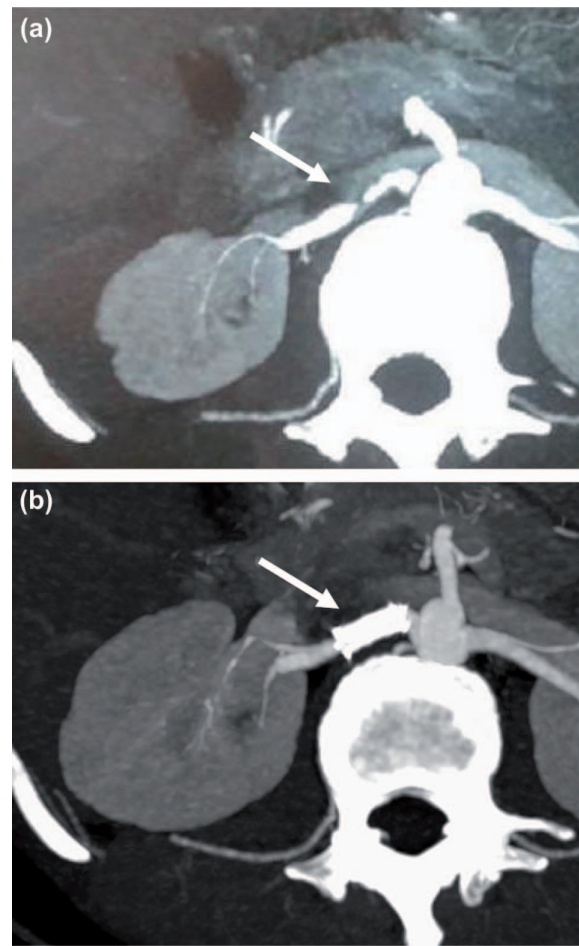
(a) Abdominal angio-CT scan showing the presence of severe stenosis (90%) in the middle segment of the right renal artery (arrow). (b) Abdominal angio-CT scan showing subsequent to percutaneous balloon angioplasty with stenting of the right renal artery: with no residual stenosis.
